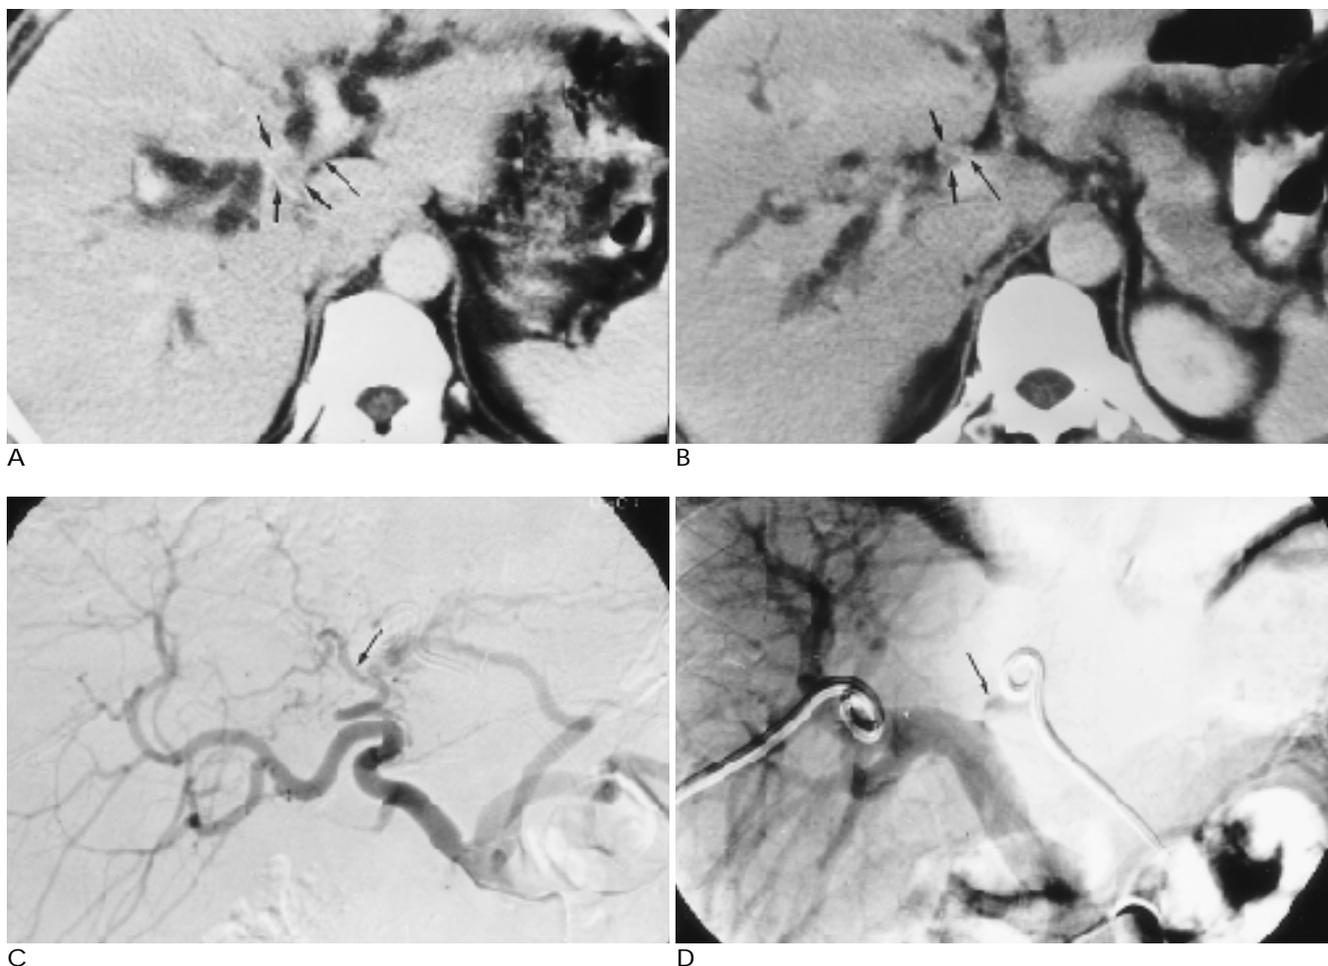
Resectable tumor erroneously diagnosed as unresectable one on the basis of CT findings.
